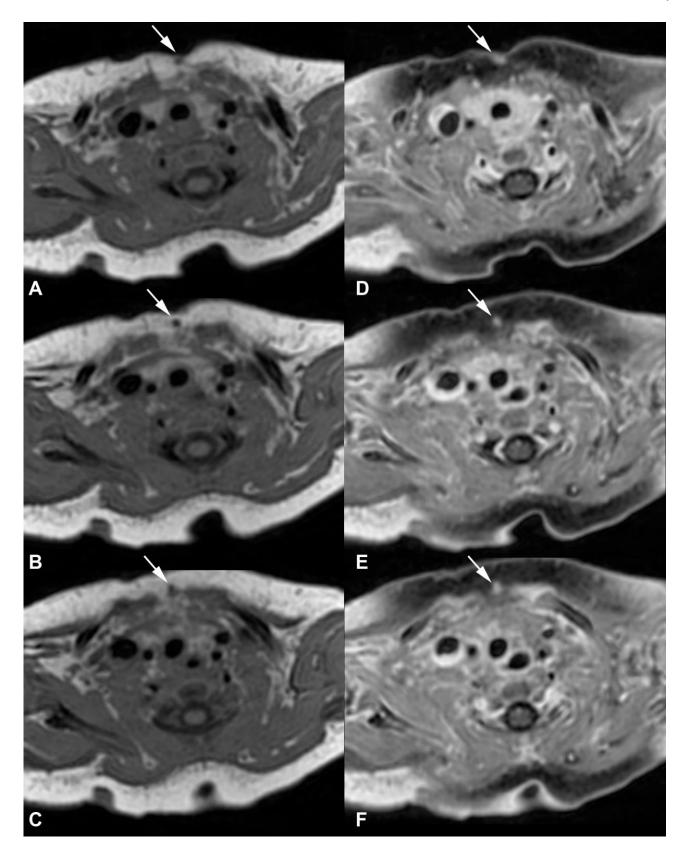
A two-day old girl with congenital midline cervical cleft. FINDINGS: Serial axial T1-weighted images (A-C) show a hypointense tract (white arrows) that enhances on corresponding axial post-gadolinium T1-weighted images with fat saturation (D-F). The tract extends cranio-caudally from the skin surface toward the manubrium of the sternum. TECHNIQUE: 3.0 Tesla MRI (GE Discovery) Images A, B, C: Axial T1 TR/TE - 600/8 ms, 1.5 mm slice thickness, noncontrast. Images D, E, F: Axial T1, TR/TE - 600/8 ms, 1.5 mm slice thickness, Gadolinium contrast 0.2 mL/kg.
